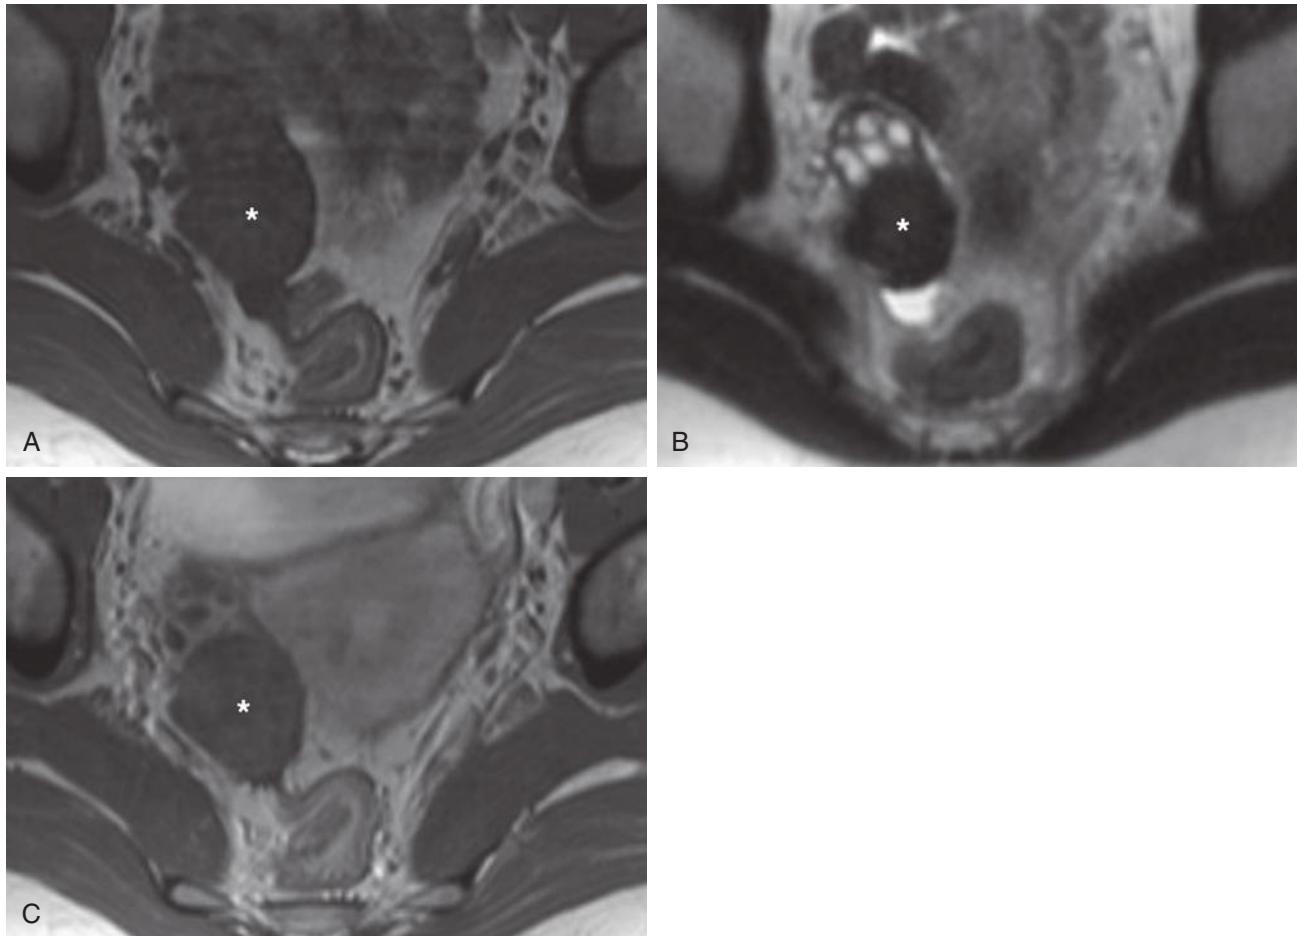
Ovarian fibroma. Axial T1-weighted (A), T2-weighted (B), and gadolinium-enhanced T1-weighted (C) images demonstrate a hypointense solid mass in the right ovary (*asterisk*). This mass has low signal intensity on both T1-weighted (A) and T2-weighted (B) images and demonstrates only slight enhancement after intravenous gadolinium administration (C), typical for an ovarian fibroma. Note numerous small hyperintense ovarian follicles anteriorly on T2-weighted image (B) that do not enhance following the administration of gadolinium (C).
